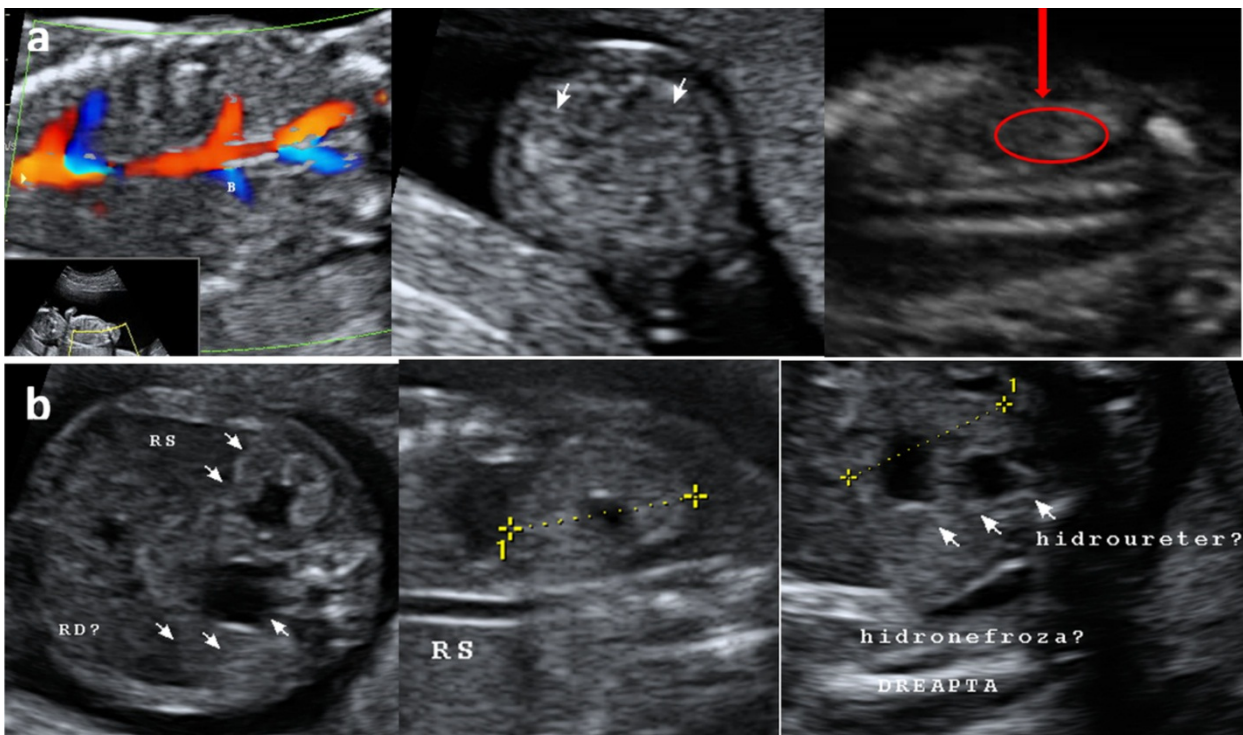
Case of unilateral MCDK, ultrasound examination negative in the FT.
